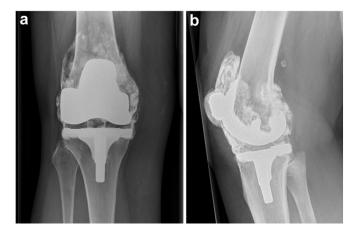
AP (a) and lateral (b) radiograph of the right CR TKA showing metallosis and a metal backed patellar component. CR, cruciate retaining; TKA, total knee arthroplasty.
